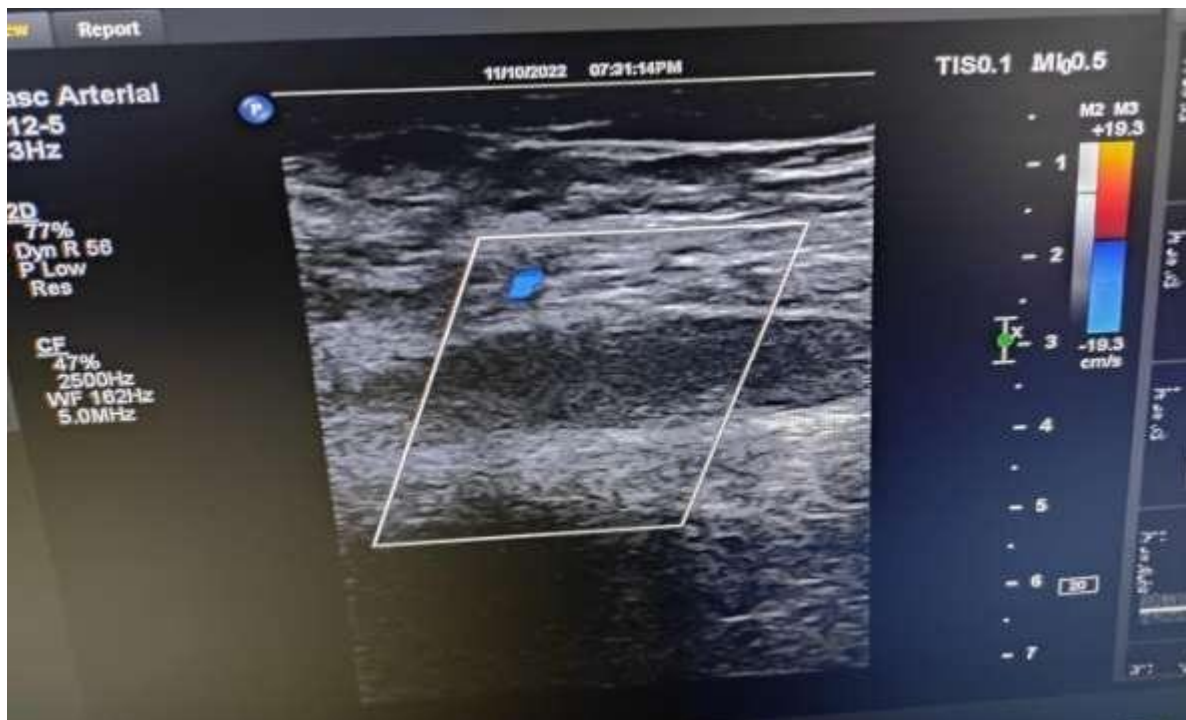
VENOUS DOPPLER OF LOWER LIMB IN COVID-19 PATIENT DEMONSTRATES NON-COMPRESSIBLE, ECHOGENIC LEFT COMMON FEMORAL VEIN WITH NO COLOR FLOW ON DOPPLER - S/O ACUTE DEEP VENOUS THROMBOSIS
